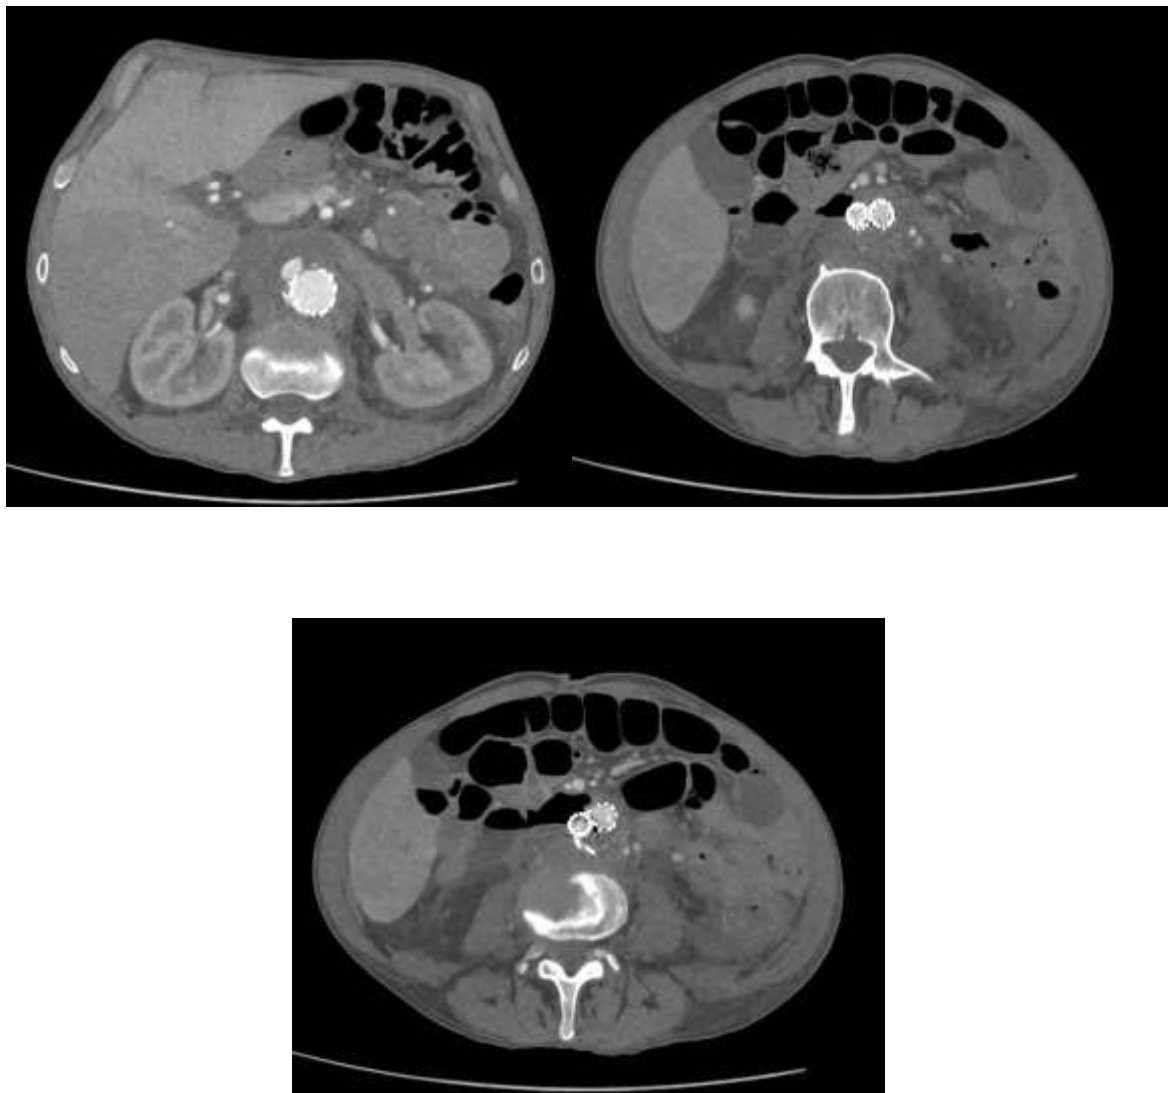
Preoperative CT scan showing aortoduodenal fistula.
